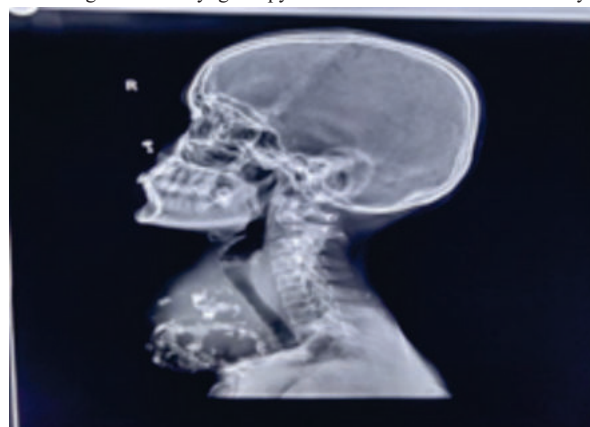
Xray neck lateral view.
